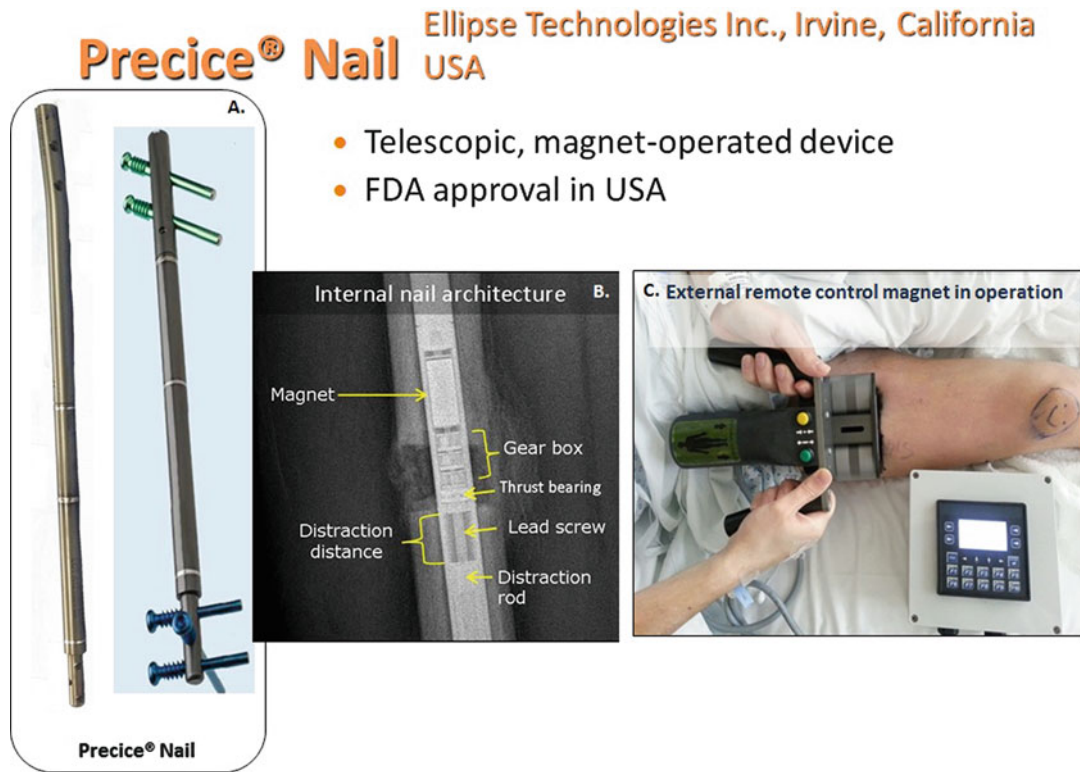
(a) Picture of the Precice nail (Ellipse Technologies, Irvine, CA, USA). (b) Anatomy of the Precice nail on X-ray. (c) Placement of the EMC on the thigh over the magnet in the nail for distraction (see Fig. 3g)
